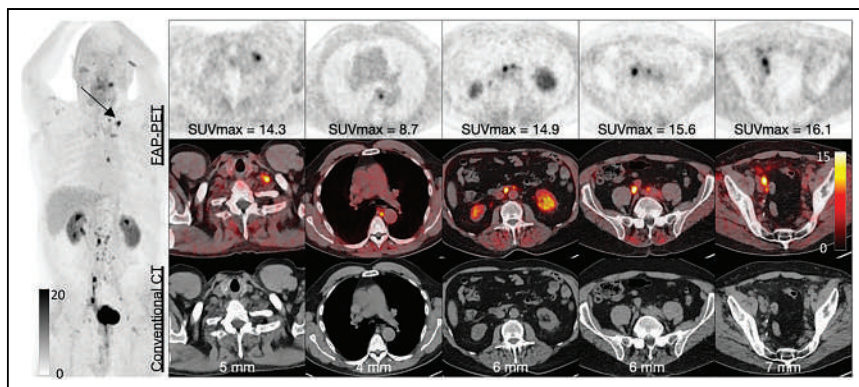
^{68}Ga -FAP-2286 PET (top and maximal-intensity projection at left), PET/CT (middle), and CT (bottom) in 76-y-old man with MIBC. Imaging revealed metastatic disease in subcentimeter lymph node not detectable by conventional CT, including disease in supraclavicular node (arrow), which was biopsy-confirmed to contain bladder cancer.
